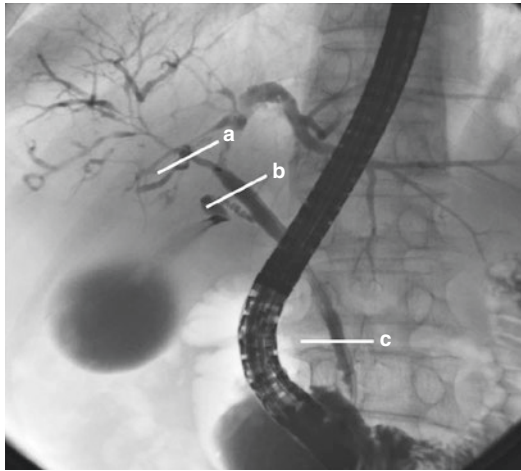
Endoscopic retrograde cholangiography (ERC) shows intrahepatic stricture in the patients with IgG4-SC. (a) Intraductal ultrasonography (IDUS) shows wall thickness in the hilar stricture. Symmetry is circular-symmetric. Outer margin is smooth. Inner margin is smooth.
